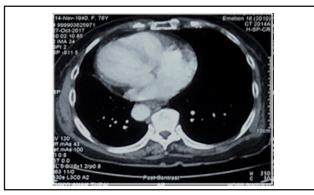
Computed tomography showing dextrocardia.
